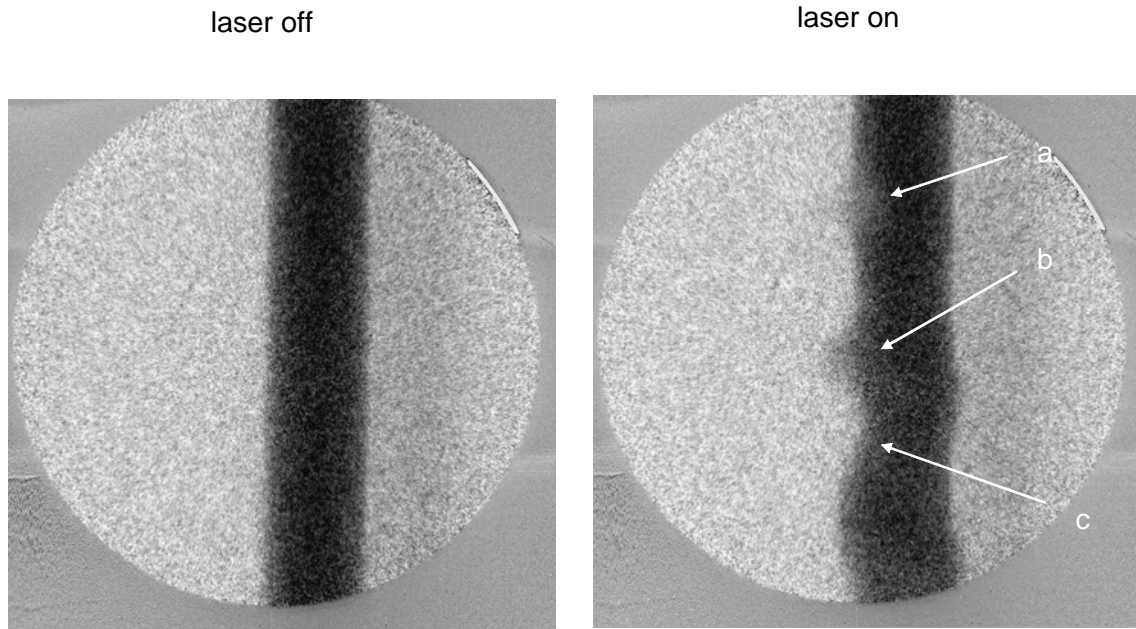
(Left) An X-ray image of a flowing stream of an aqueous carbon suspension. (Right) X-ray image of the carbon suspension synchronized with the firing of the laser. The point marked (a) corresponds to the position where the laser beam is focused.
